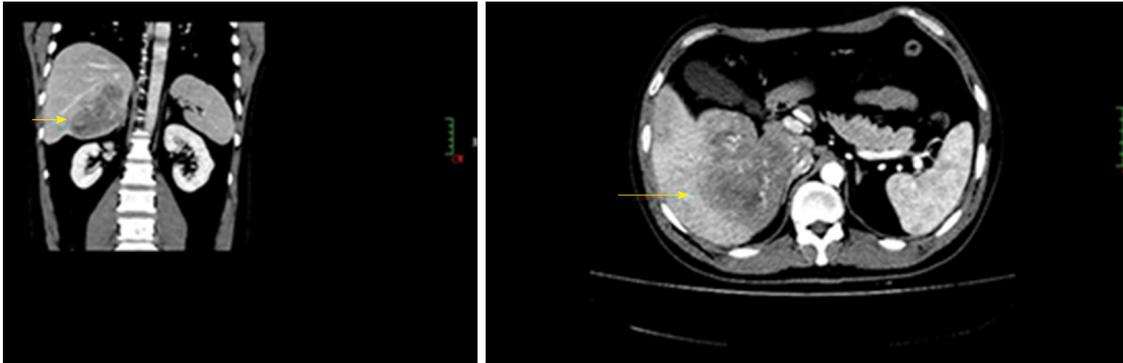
Abdominal computed tomography examination. The images show an ill-defined and low-density 10 cm mass (arrows) in the right lobe of the liver, accompanied with enlargement of hepatic portal lymph nodes.
